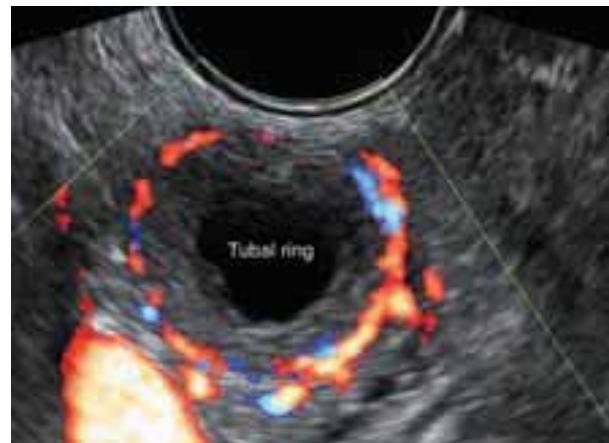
Transvaginal ultrasound with color flow Doppler imaging. Increased blood flow ('ring of fire' appearance) seen around the ectopic pregnancy. (Photo courtesy: Mediscan Systems, Chennai.)
